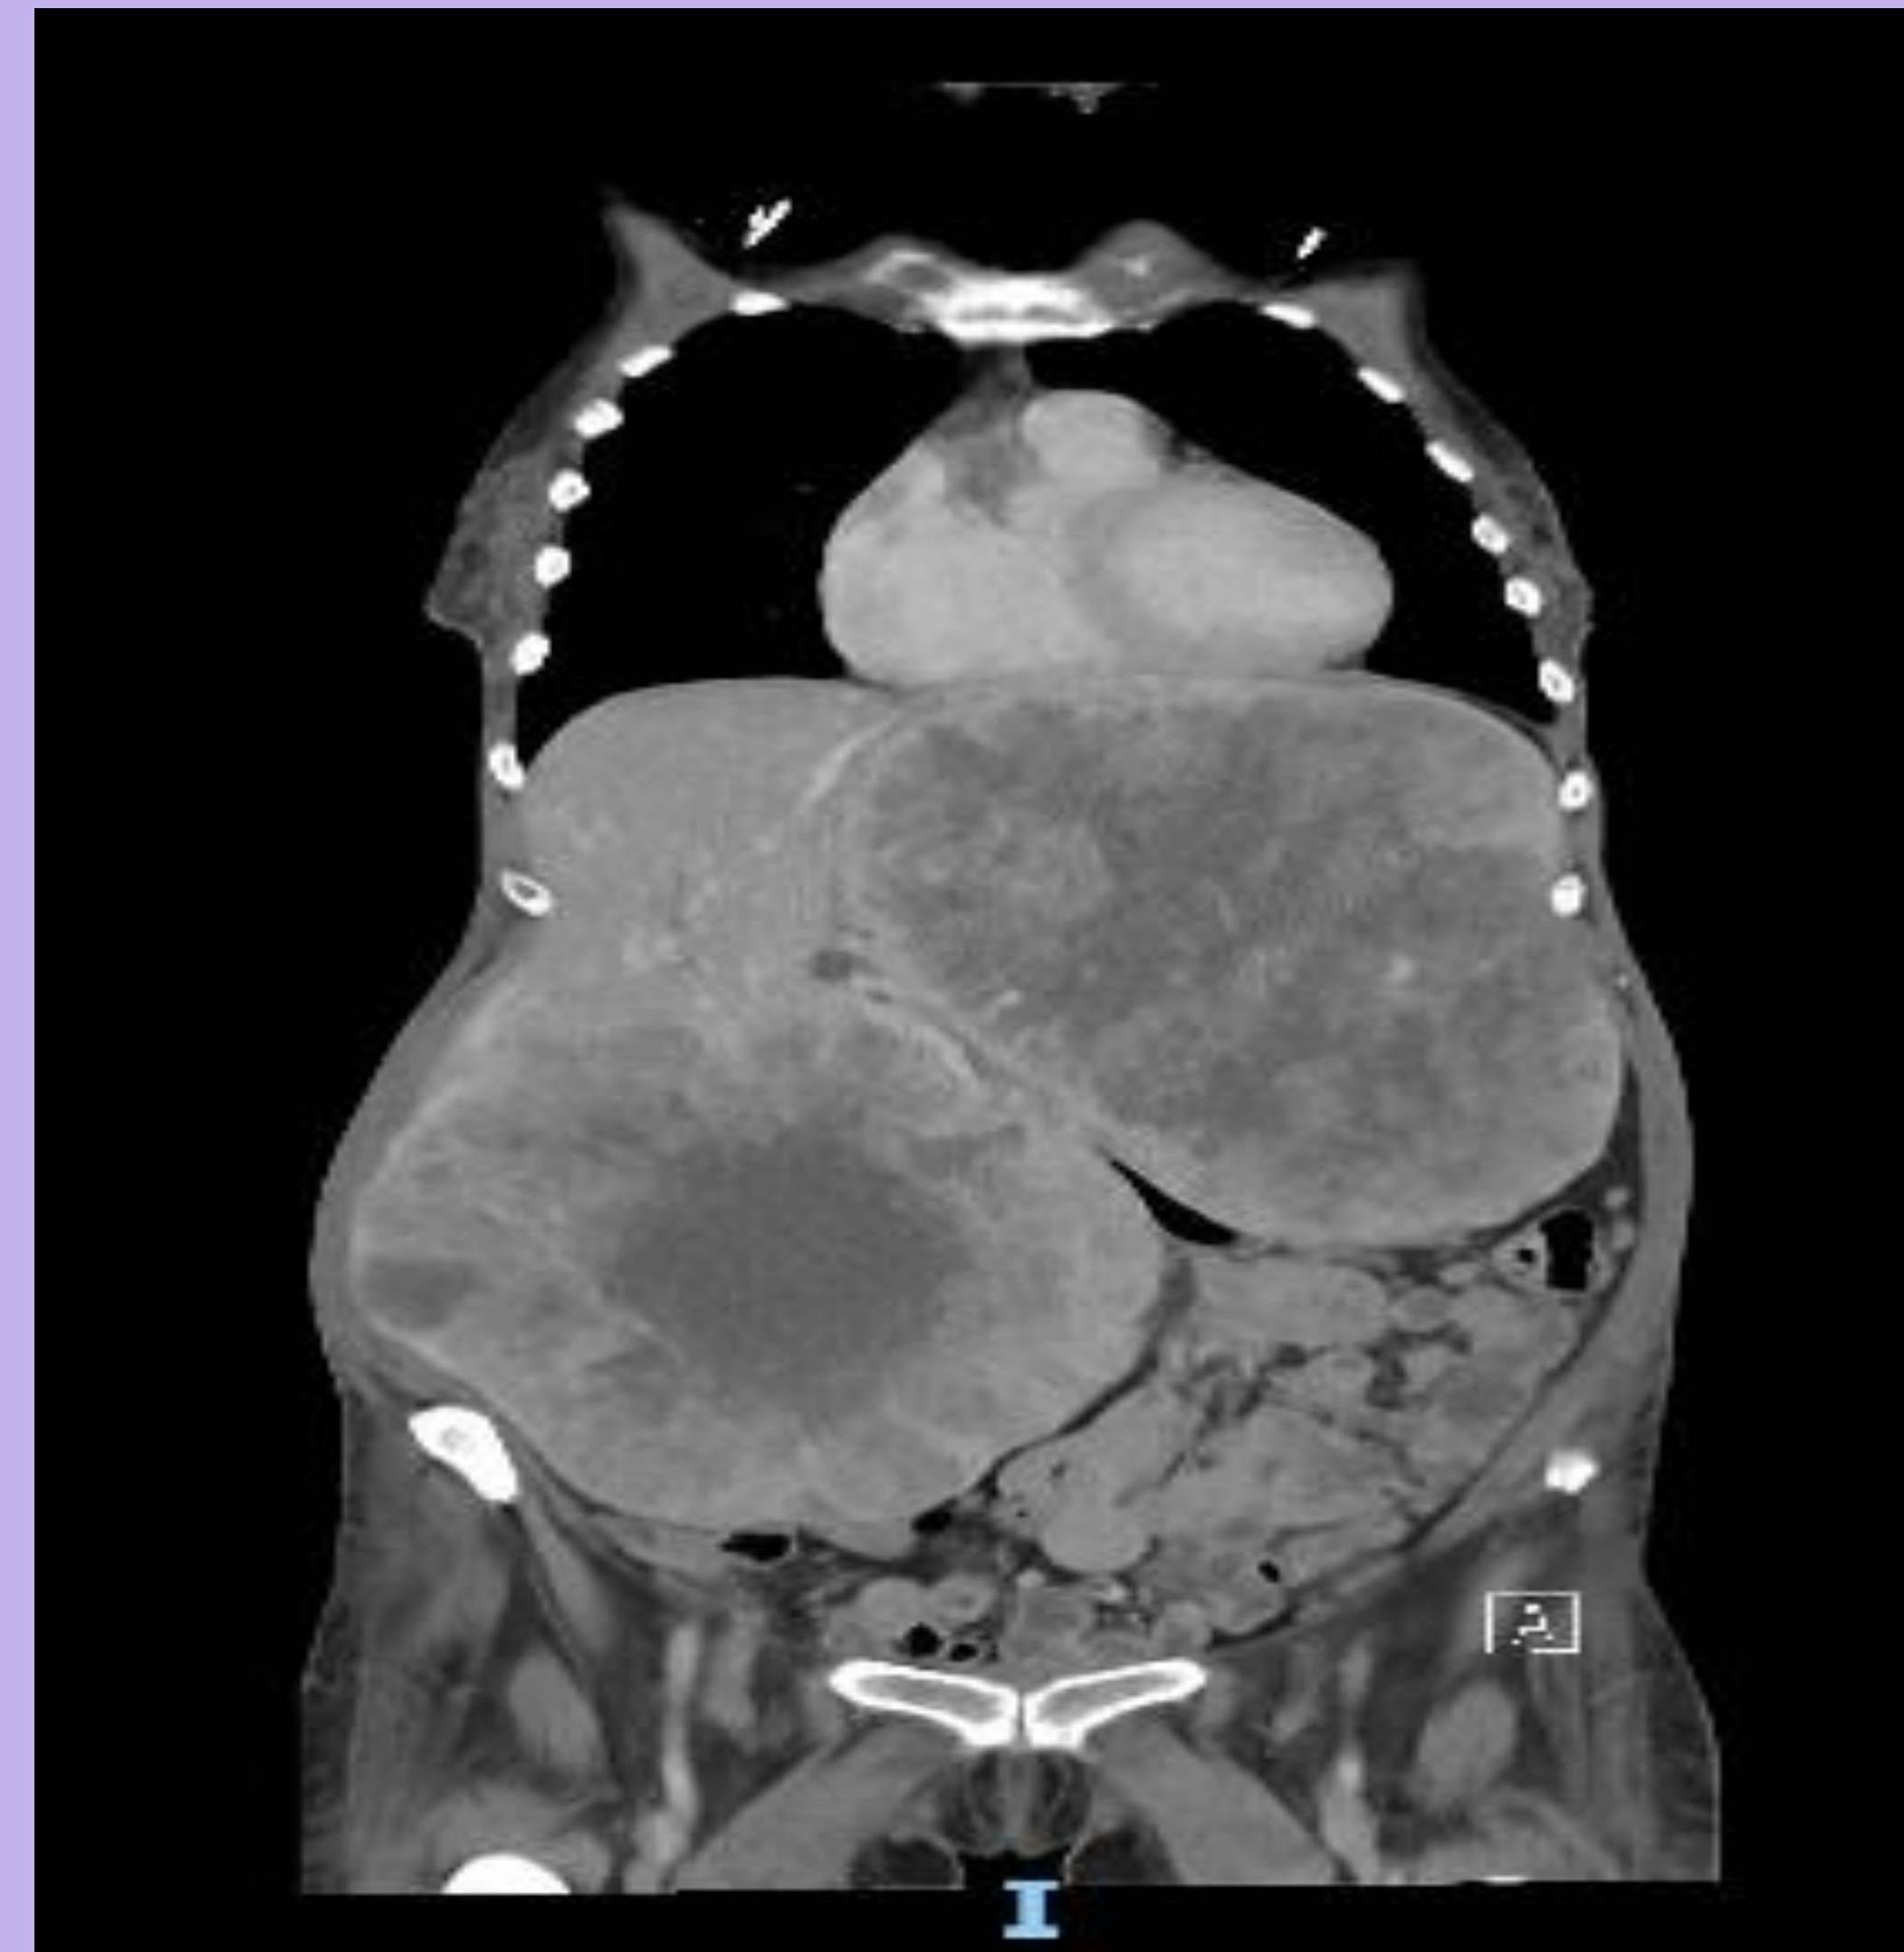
Coronal CT demonstrating two large hepatic masses with heterogenous enhancement
